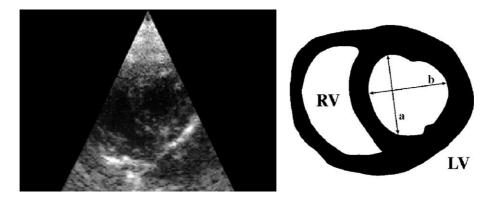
Parasternal short-axis view by two-dimensional echocardiography, and an index of pulmonary hypertension in the parasternal short-axis of the left ventricle. RV=right ventricle, LV=left ventricle.
